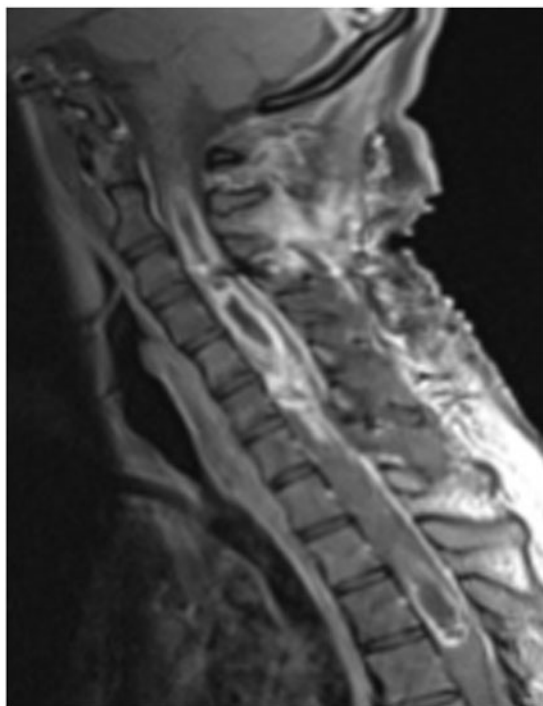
Cervical sagittal T1 MRI with contrast demonstrating the intra-axial enhancing lesion of the cord.
